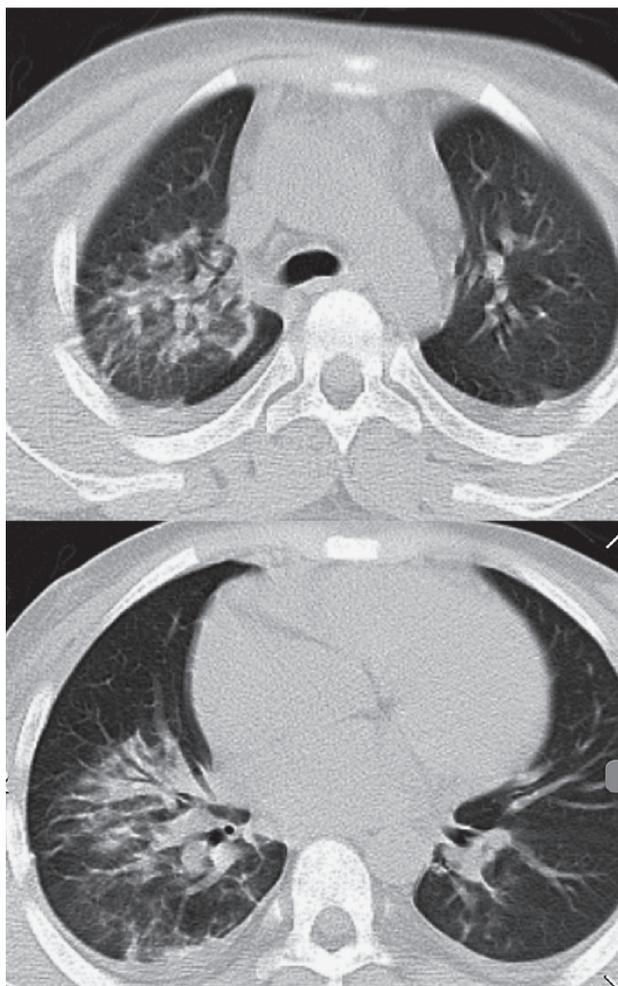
Axial Chest CT Scan (Consolidation & Ground Glass Opacity with Peribronchovascular Pattern)
